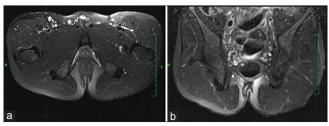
(a and b) T2-weighted FS axial and coronal: Inter-sphincteric fistula in ano with external opening at 7 o' clock position in right buttock and internal opening at 11 o' clock position of anal canal
